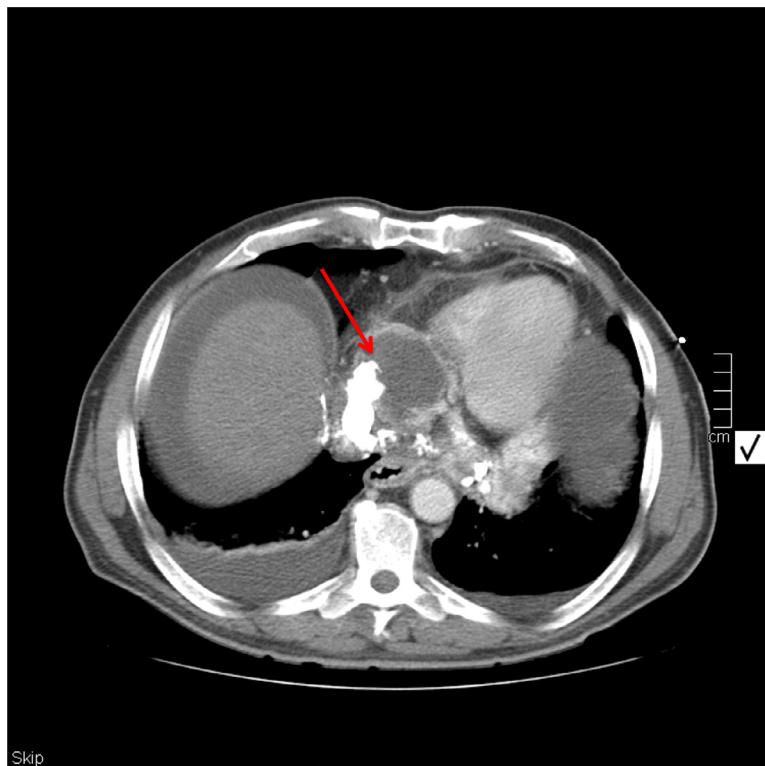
Abdomen/pelvis CT with contrast showing right atrial sarcoma extending into inferior vena cava (red arrow).
